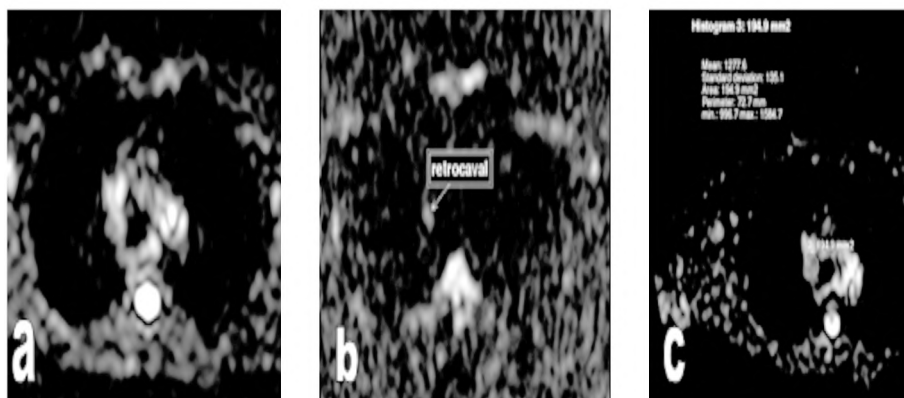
Axial DWIBS images at the same level in Fig. (5): (A) Axial b0 DWI (B) b1000 DWI and (C) ADC map demonstrating the retrocaval lymph node yet without restricted diffusion. ADC = 1.277 x 10⁻³ mm²/sec.
